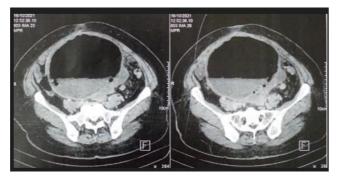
CT slice displaced abscess measuring 200x154mm of left ovarian origin.
